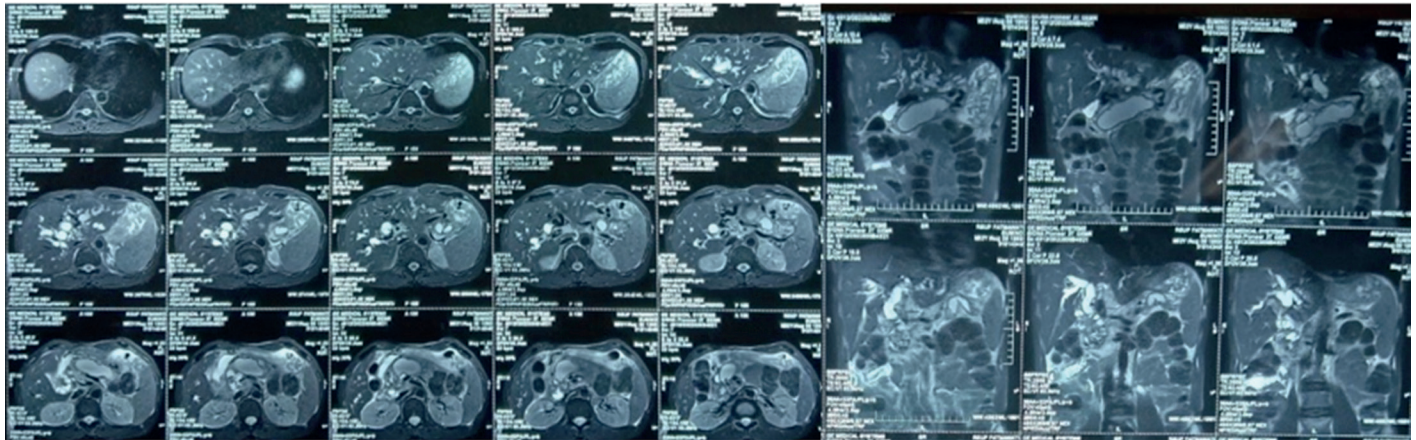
MRI examination result showed prominent dilatation of the right and left intrahepatic ducts, and common bile duct due to massive dilatation of the main pancreatic duct, accompanied by an irregular filling defect that adhesions to the wall
